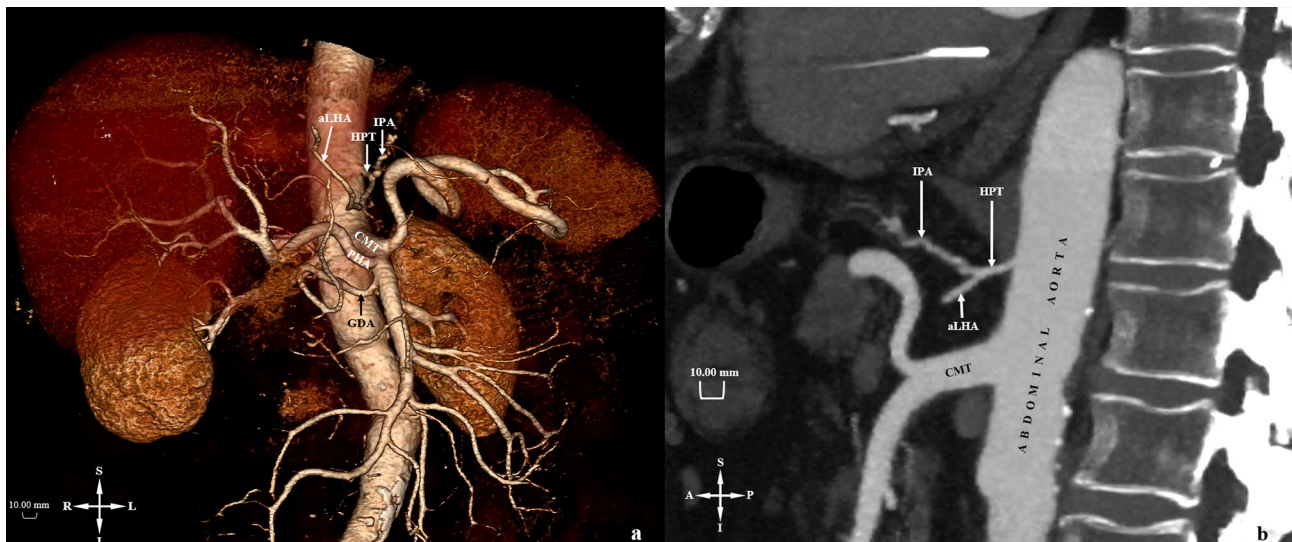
a 3D image of hepatic artery variation on CT. b Sagittal plane image of hepatic artery variation on CT aLHA: Accessory left hepatic artery; A: Anterior CMT: Celiacomesenteric trunk; GDA:
